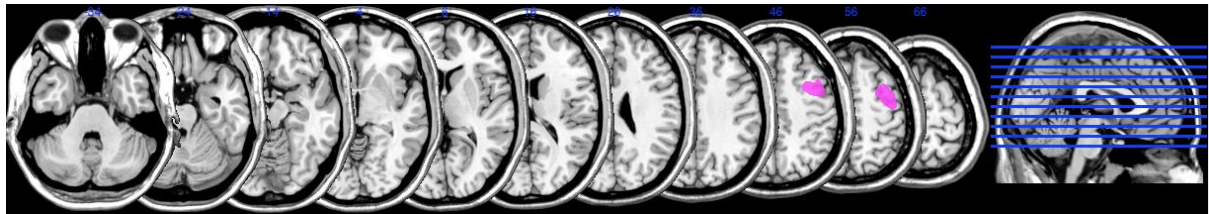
MRI Scan of patient LW
